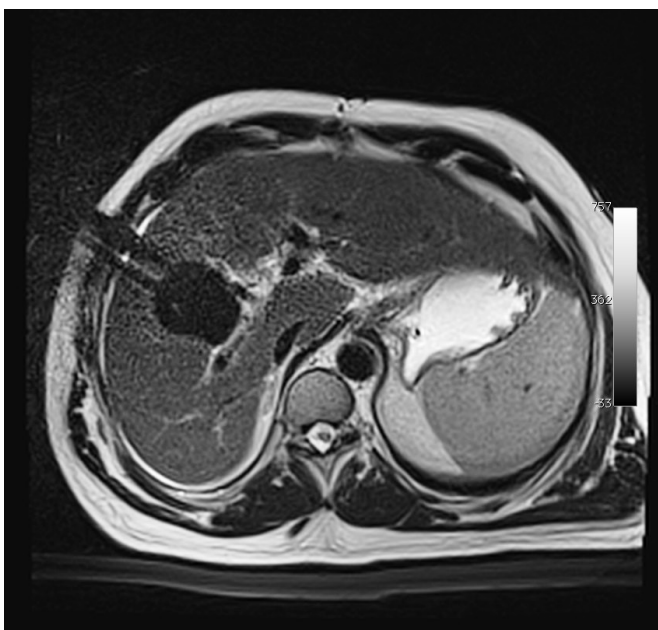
Liver MRI – T2 axial plane. 2 cryotherapy probe.
